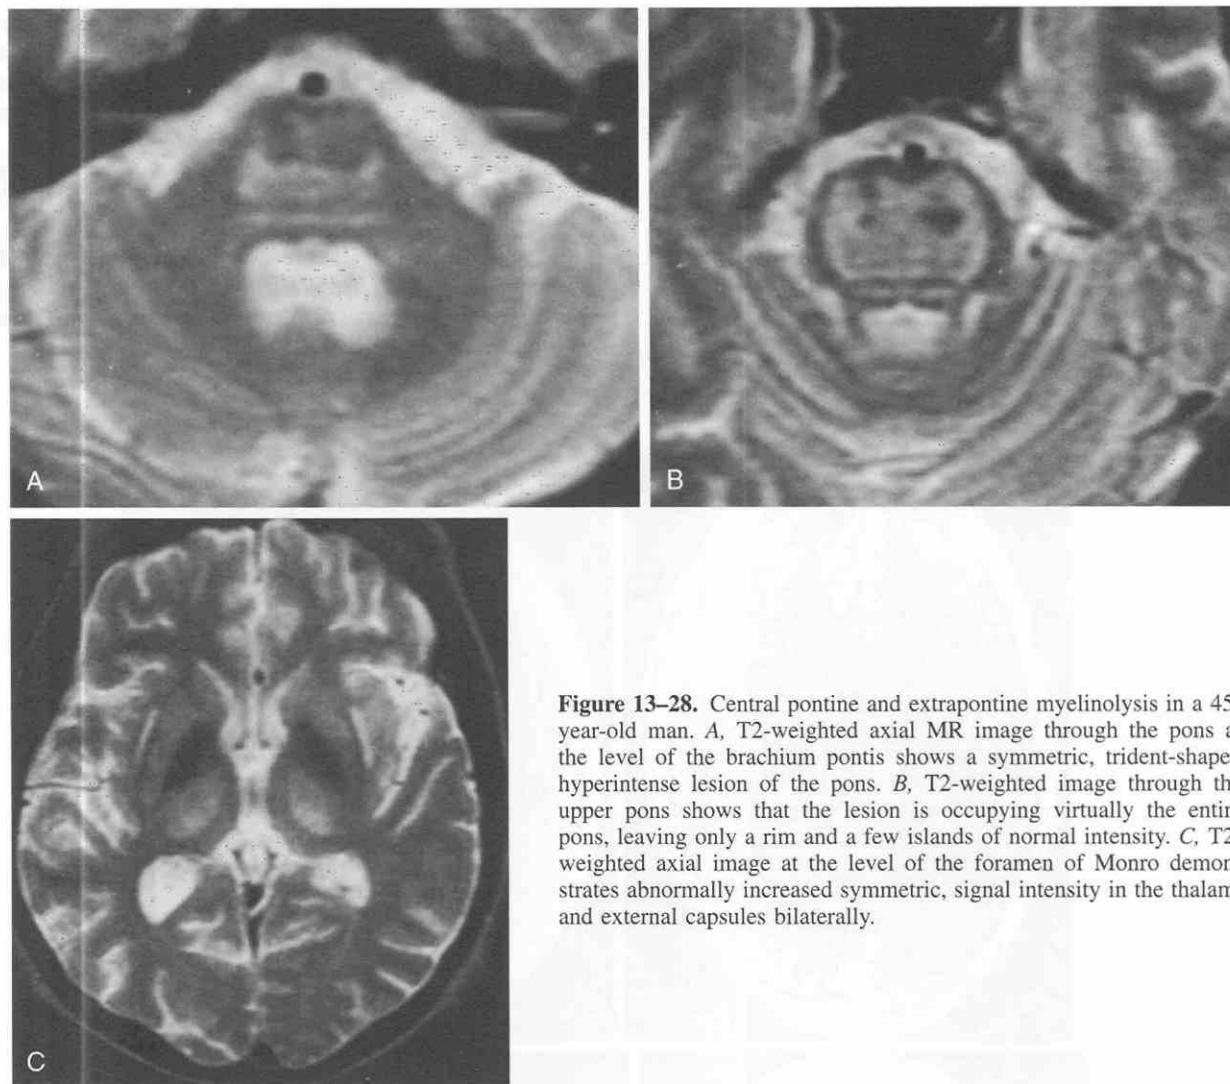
Central pontine and extrapontine myelinolysis in a 45-year-old man. *A*, T2-weighted axial MR image through the pons at the level of the brachium pontis shows a symmetric, trident-shaped hyperintense lesion of the pons. *B*, T2-weighted image through the upper pons shows that the lesion is occupying virtually the entire pons, leaving only a rim and a few islands of normal intensity. *C*, T2-weighted axial image at the level of the foramen of Monro demonstrates abnormally increased symmetric signal intensity in the thalami and external capsules bilaterally.
